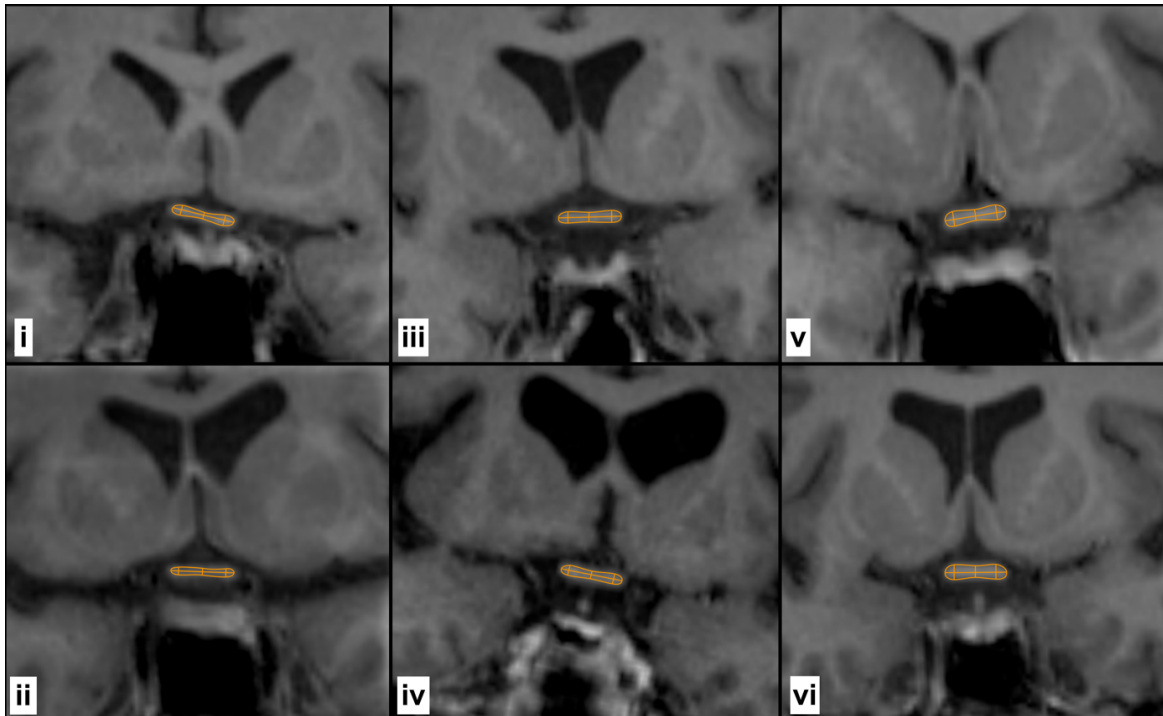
Sample MRI measurements of optic chiasm dimensions
